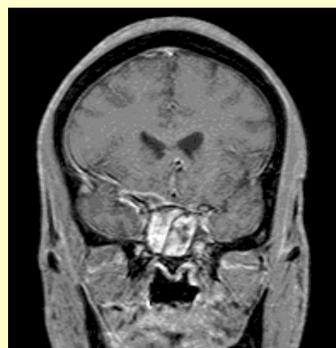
(Right): Coronal T1 MRI demonstrating epidural enhancement on the right.
